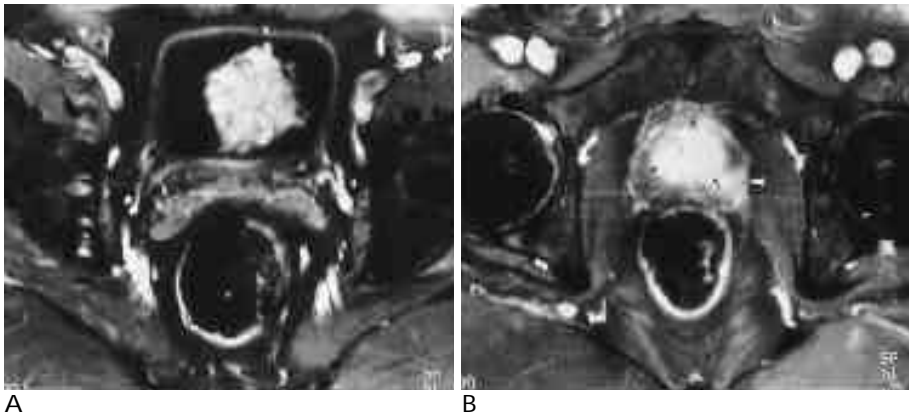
MRI performed at the time of initial diagnosis of bladder cancer (two months prior to figure 2)
